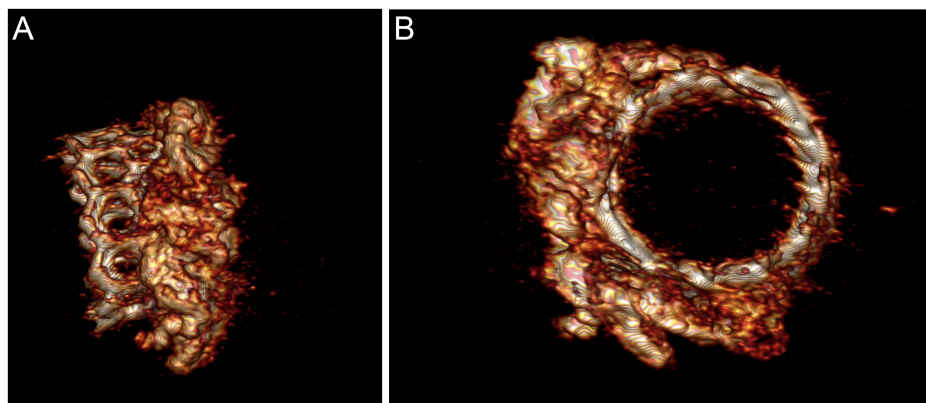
Postprocedural computed tomography demonstrating the relationship between the implanted valve and severe mitral annular calcification in en-view (A) and en-face (B) orientations.
